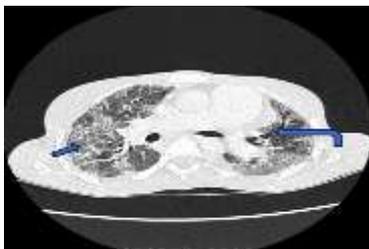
Axial HRCT of the chest showing ground glass appearances with mosaic attenuation (straight arrow) and traction bronchiectasis (Bend arrow) in the upper lobes.
